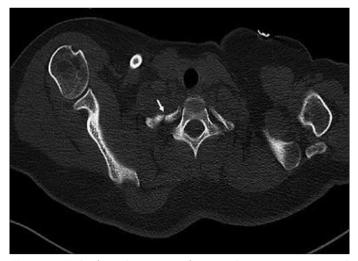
Right first rib posterior fracture showing on computed tomography, (white arrow)
